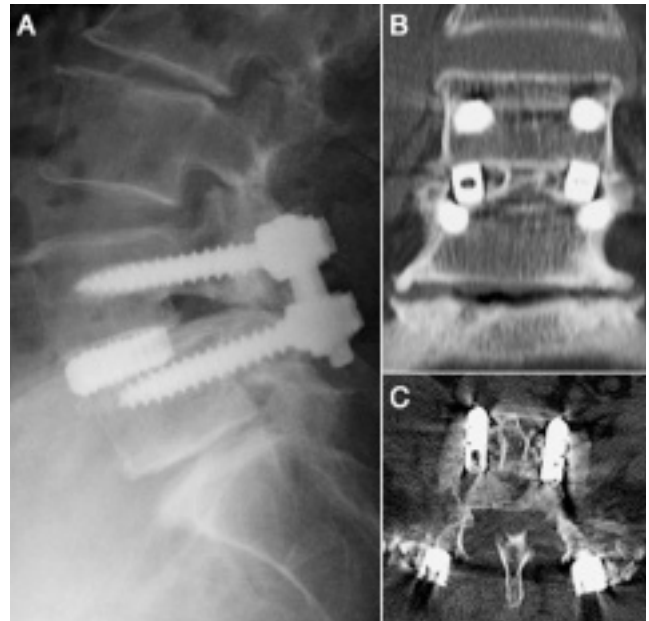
A case of 76-year-old woman with L4 spondylolisthesis. A, Post-op lateral radiograph of the lumbar spine at follow-up. The slip was reduced and the disc space height was improved. B, Coronal reconstruction of CT scan. The union of intervertebral grafted bone could be confirmed. C, Axial view on CT scan. Titanium intervertebral spacers were placed antero-laterally.
